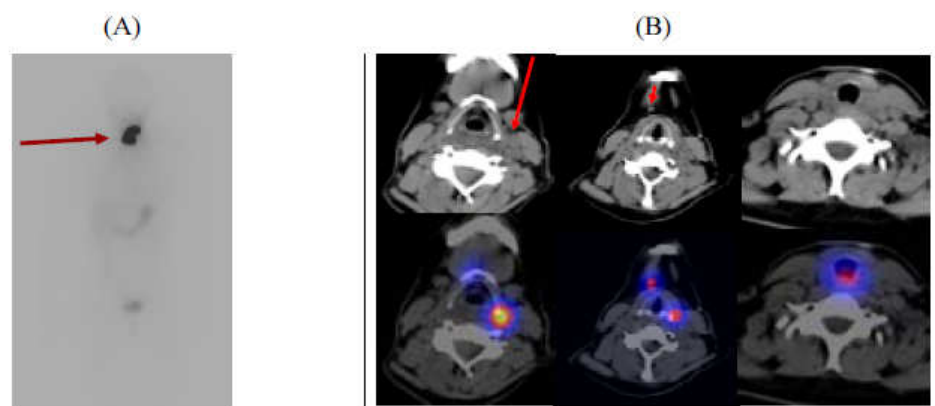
(A) SPECT/CT in thyroid cancer. The planar scan post-radioiodine ablation of thyroid remnants shows radioiodine-avid tissue in the neck of a patient after total thyroidectomy, without the possibility of discriminating ^{131}I uptake in remnant normal thyroid parenchyma from possible lymph node metastasis. (B) SPECT/CT demonstrates two cervical lymph nodes in this patient (arrows) that cannot be differentiated from benign remnant tissue in the planar scan [164].
